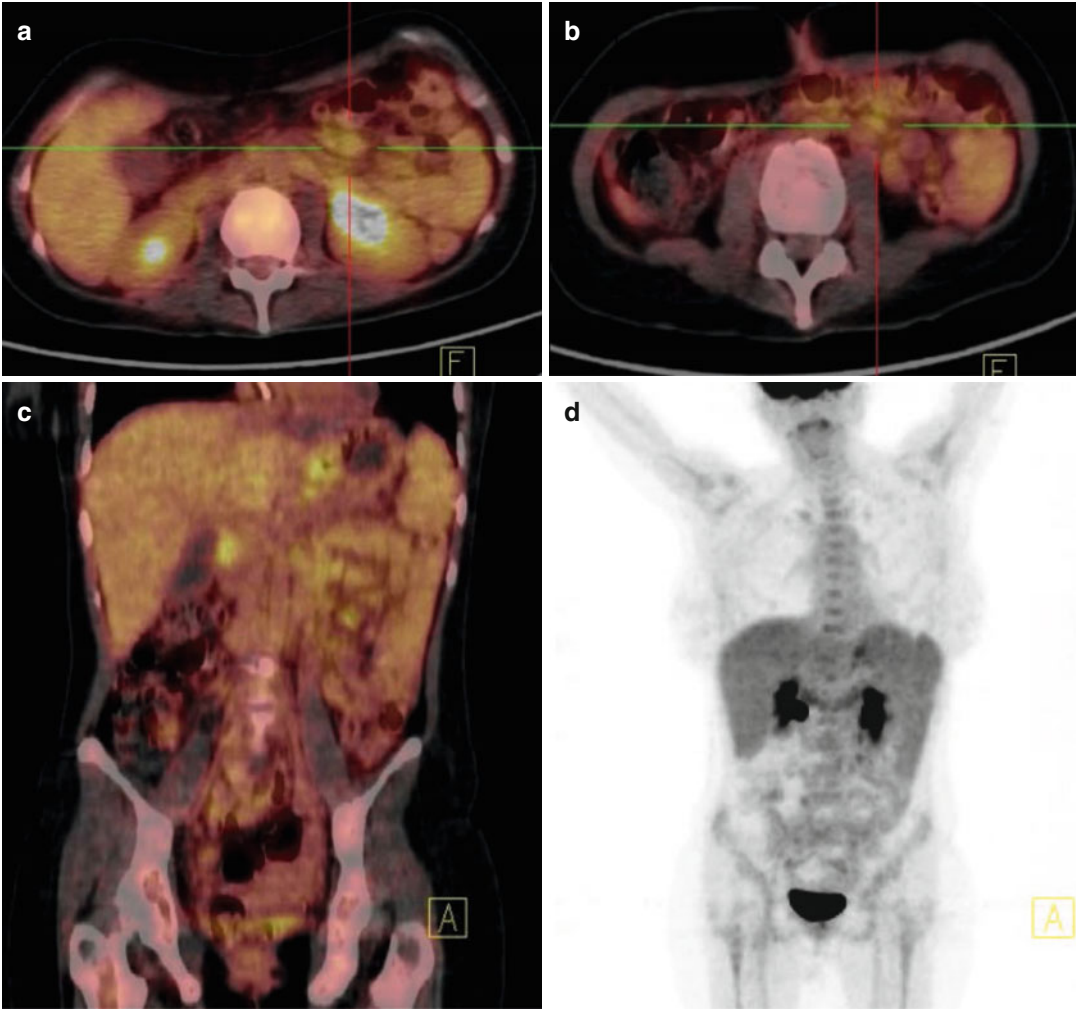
Interim PET/CT shows mild hypermetabolic mesenteric lymph nodes, which were however interpreted as positive by the Deauville 5-point scale (score: 4) (a–d)
